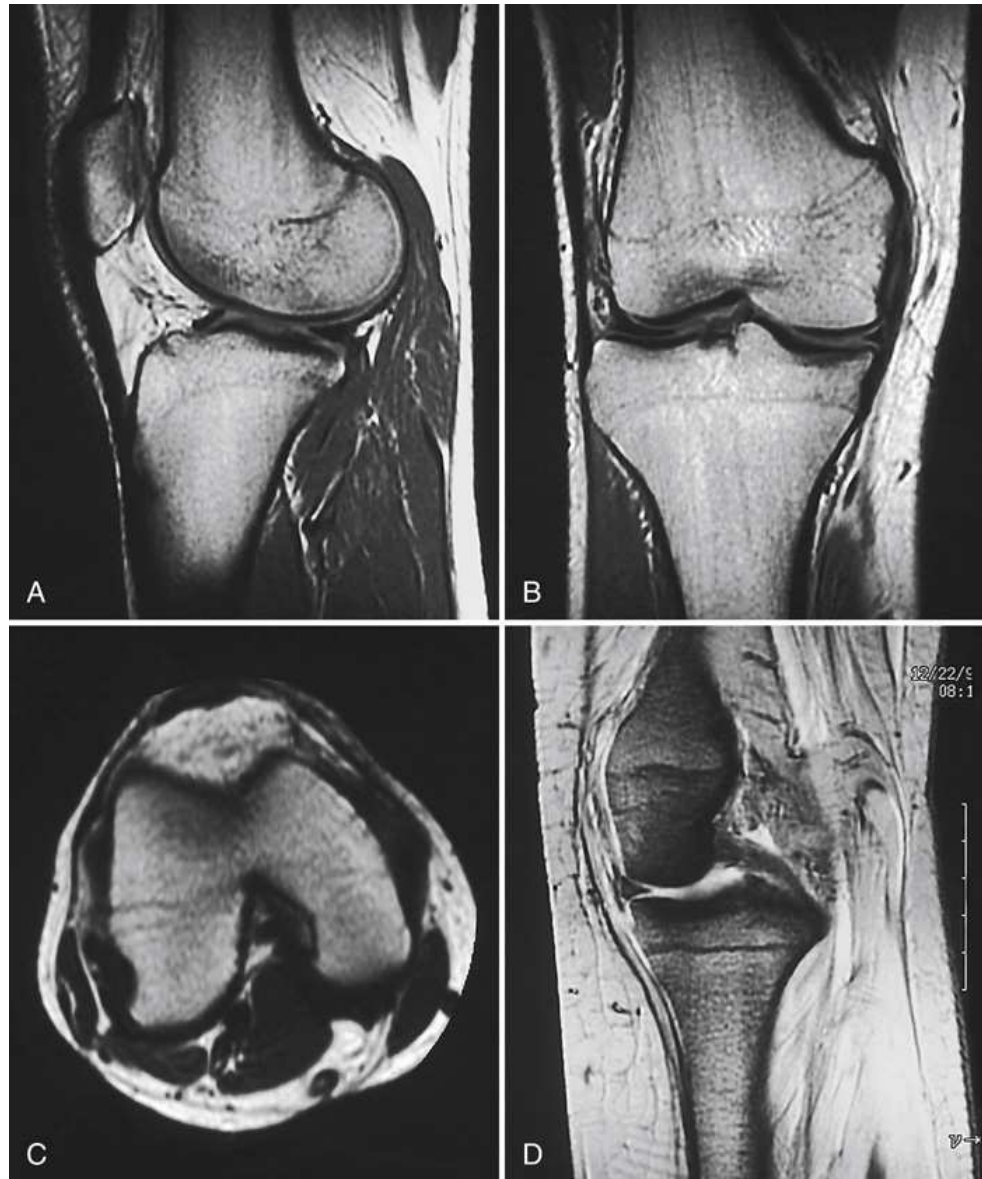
MRI of the knee in four planes. (A) Sagittal. (B) Coronal. (C) Horizontal. (D) Oblique, 45 degrees.
